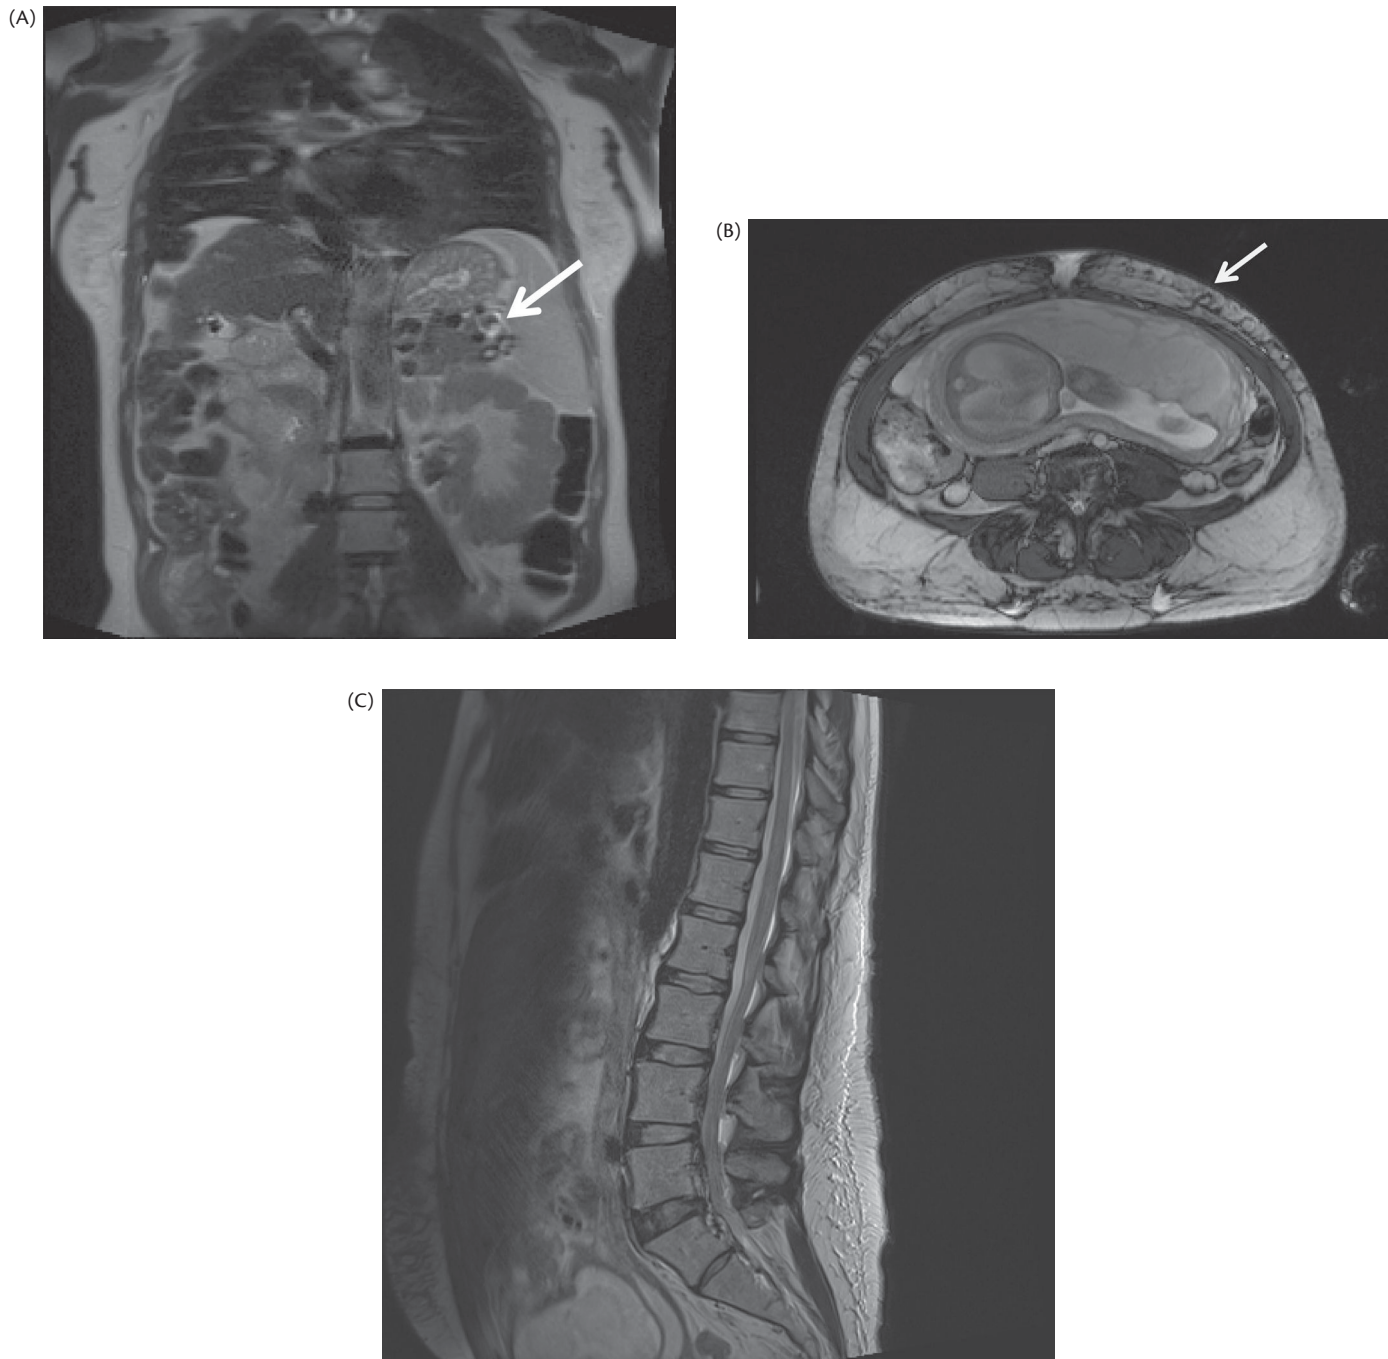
MRI of a 37-year-old patient with cirrhosis (alfa-1-antitrypsin deficiency) at 32 weeks of gestation. Delivery 2 weeks later by uneventful caesarean section because of intrauterine growth retardation. (A) Coronal image showing small cirrhotic liver, ascites, and collateral veins (arrow) in the splenic hilum, perigastric, and pericolic area. (B) Pregnant uterus and venous collaterals in the anterior abdominal wall (arrow). (C) Normal epidural space, no venous collaterals.
